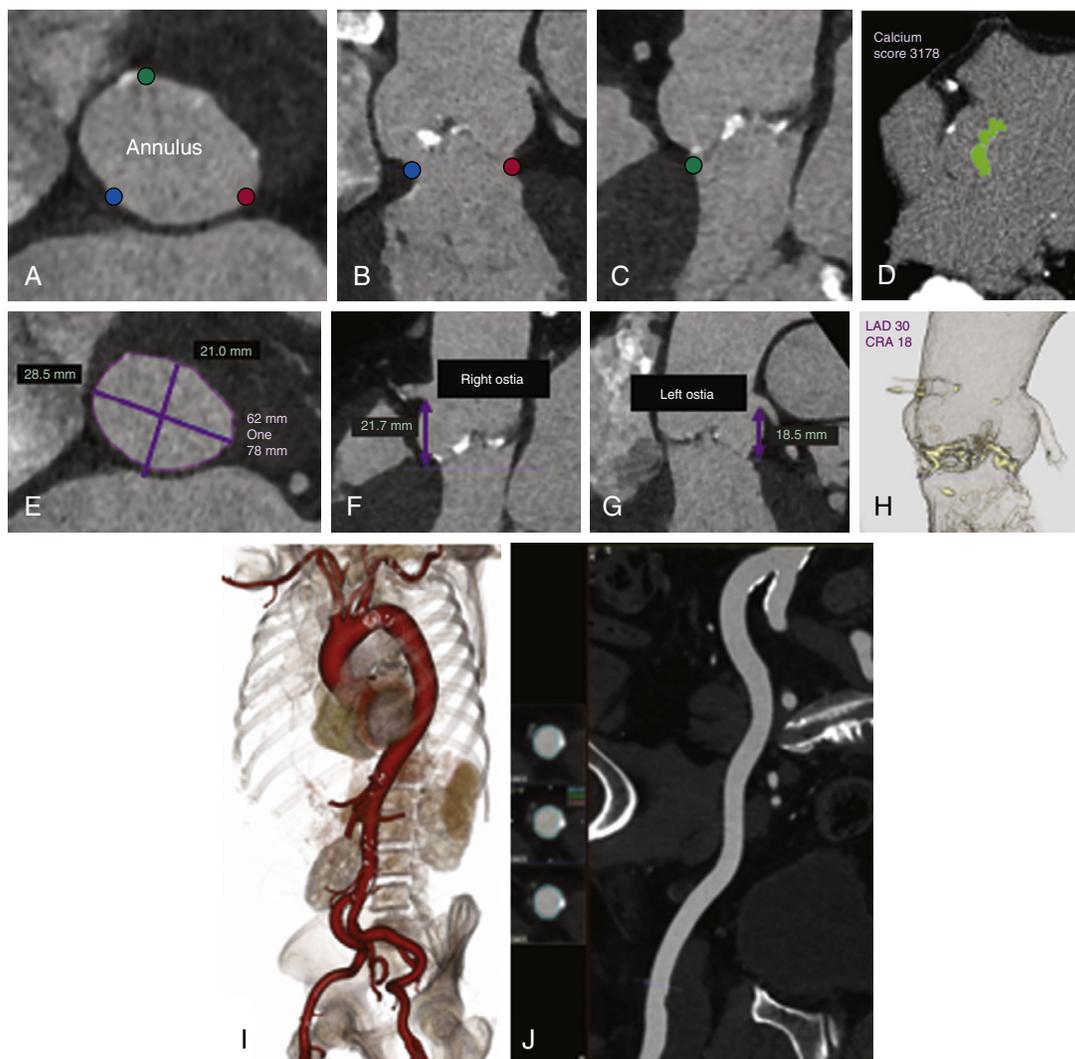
Cardiovascular computed tomography for preprocedural planning of transcatheter aortic valve replacement (TAVR). A, Short-axis view of the aortic annulus to mark the nadir of each cusp (green, right cusp; red, left cusp; blue, noncoronary cusp). B and C, Corresponding long-axis views of the aortic root showing the correct placement of the markers on the nadirs. D, Aortic valve calcium score for stenosis severity. E, Annulus view for major and minor axis diameters, area, and perimeter. F and G, Coronary ostia height measurements. H, Three-dimensional virtual reality (3DVR) showing the en face annular plane for TAVR deployment planning. I, 3DVR for access vessel tortuosity and calcification. J, Curved multiplanar reformat for access vessel diameters. (Courtesy Michael Steigner, Brigham and Women's Hospital, Boston, MA.)
